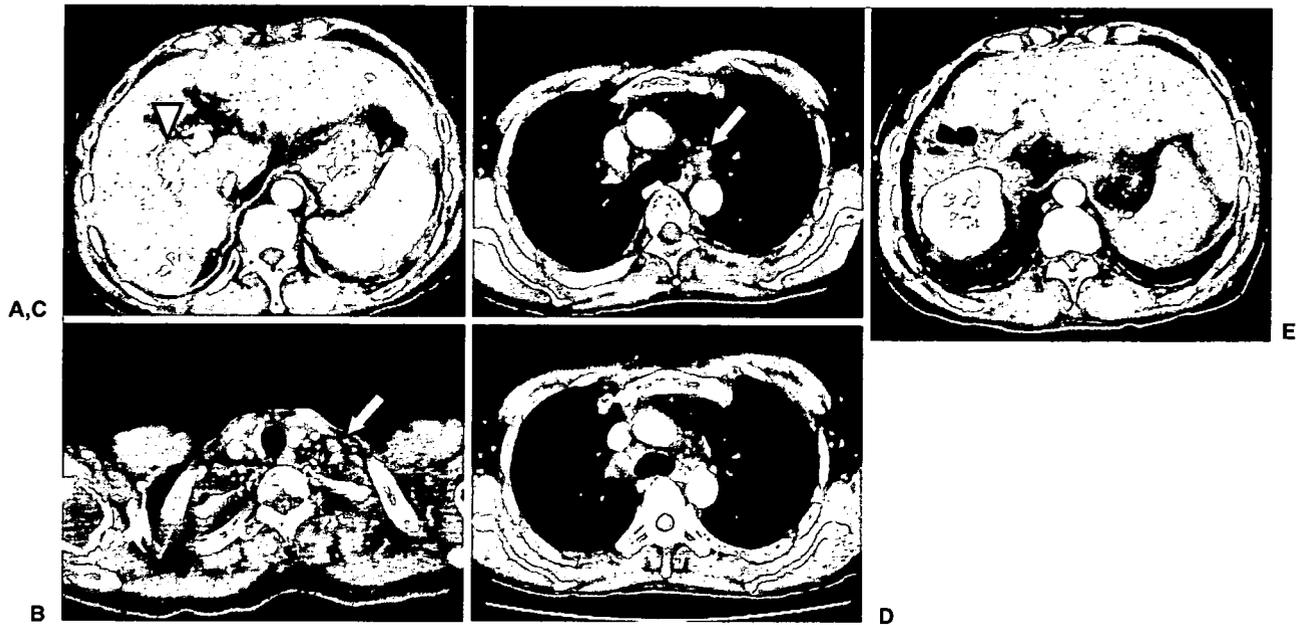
CT of case 2. A The main tumor is an early enhanced area occupying the whole right lobe of the liver, and the tumor thrombus has invaded the right main branch of the portal vein (*arrowhead*). B Cervical CT scan showing the enlarged supraclavicular lymph node (*white arrow*). C Chest CT scan shows the enlarged mediastinum lymph nodes (*white arrow*). D After three cycles of interferon- α /5-fluorouracil combination therapy, the mediastinum lymph nodes had diminished in size. E Residual tumors in the left lobe of the liver disappeared and there was no recurrence in the liver 12 months after hepatectomy
